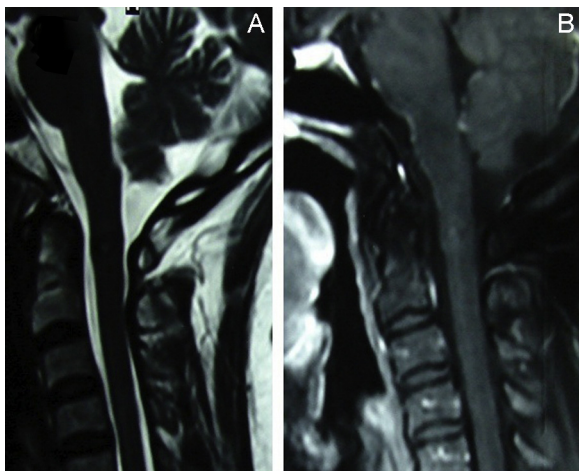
(A and B) MRI of cervical spine T2W and T1W+contrast sagittal images (done four months after start of ATT) showing significant resolution of the lesion.
